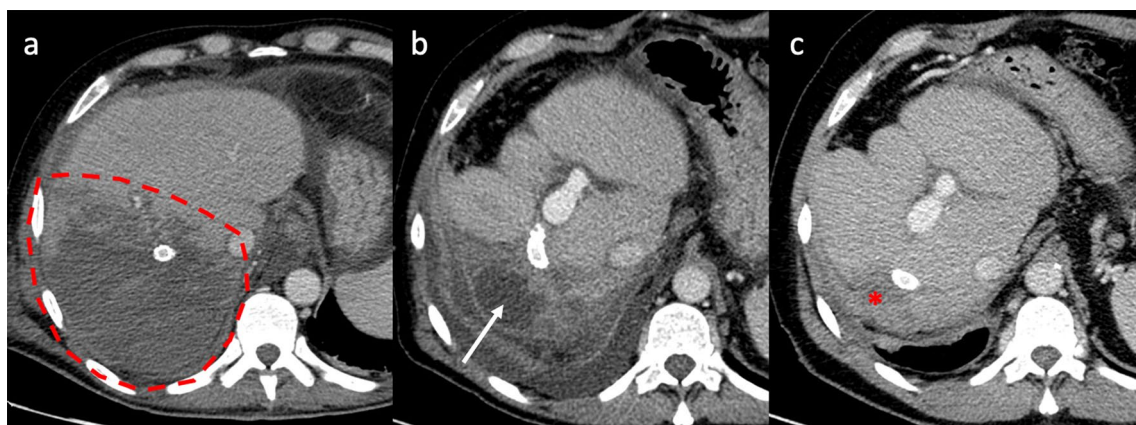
Liver ischemia. Axial contrast-enhanced CT images (a, b), exhibit a large hypodense hepatic area of infarct (red line) complicated by abscess (arrow). Contrast-enhanced CT imaging performed
